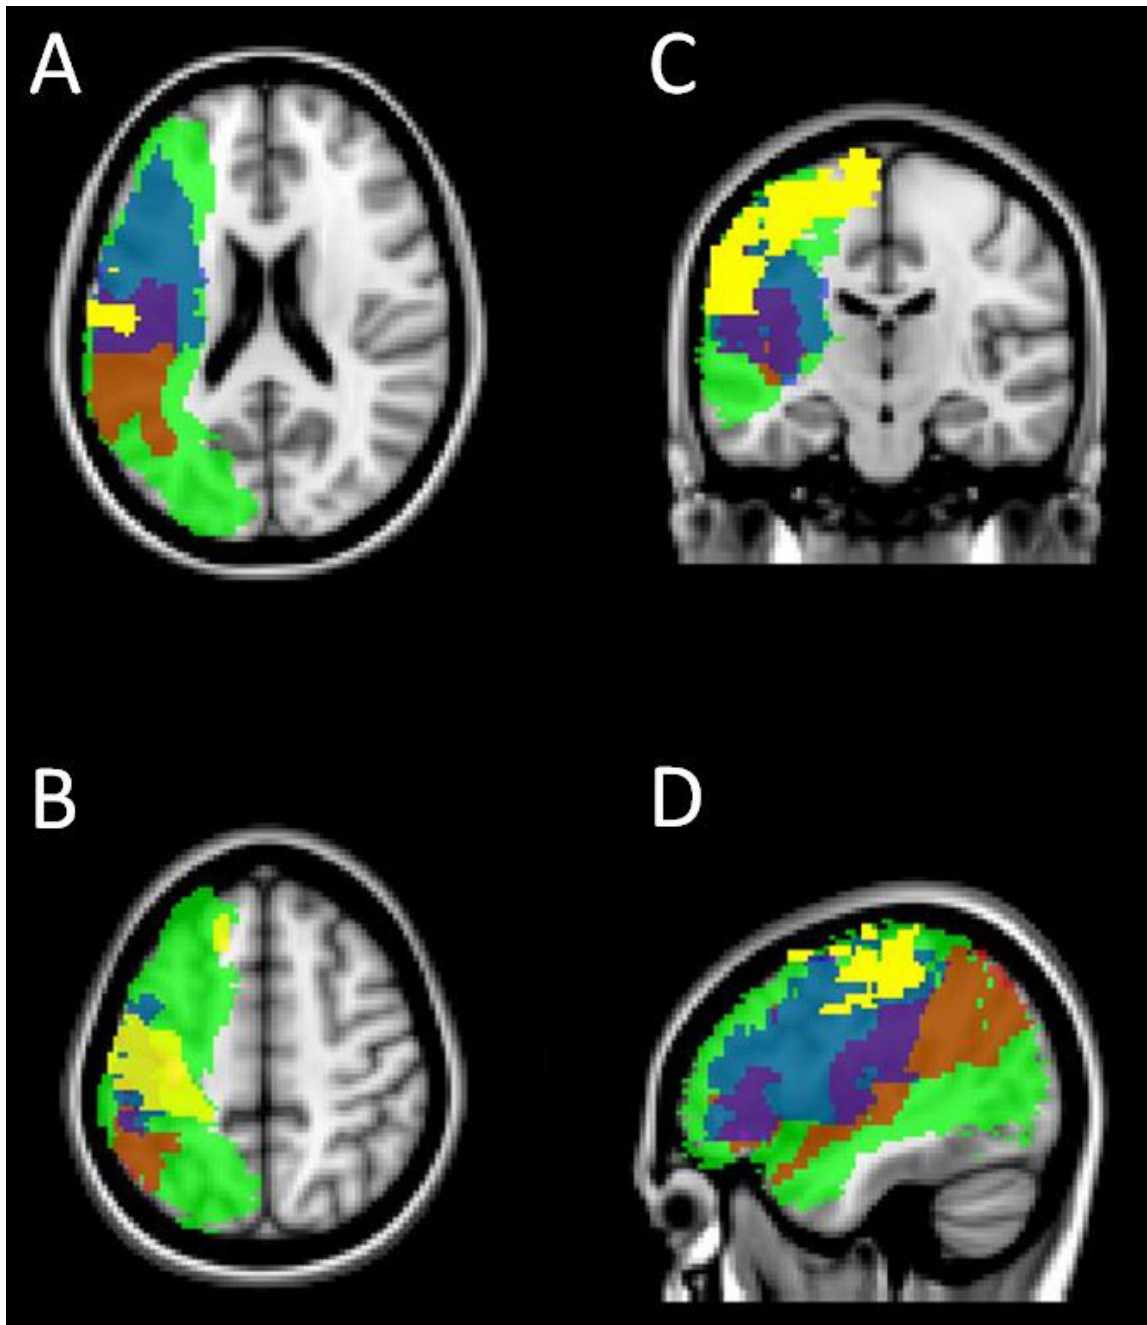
Structural MRI (FLAIR sequence). Overlay of normalized lesion maps of the patients in the standard brain.
